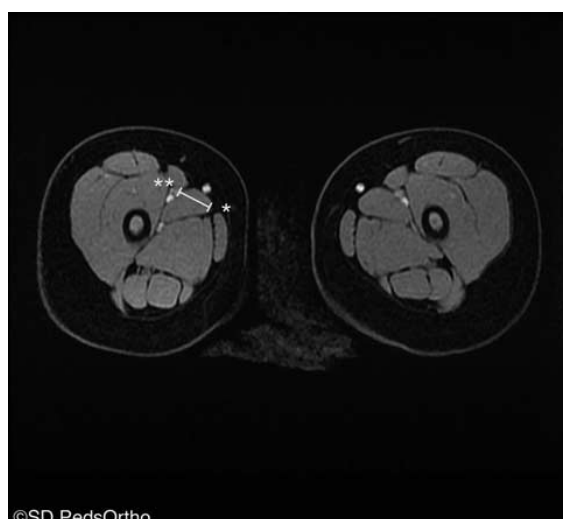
Axial magnetic resonance imaging sequence demonstrating the line drawn to measure the distance from the needle insertion (*) (or the cone vertex) to the femoral neurovascular structures ().
